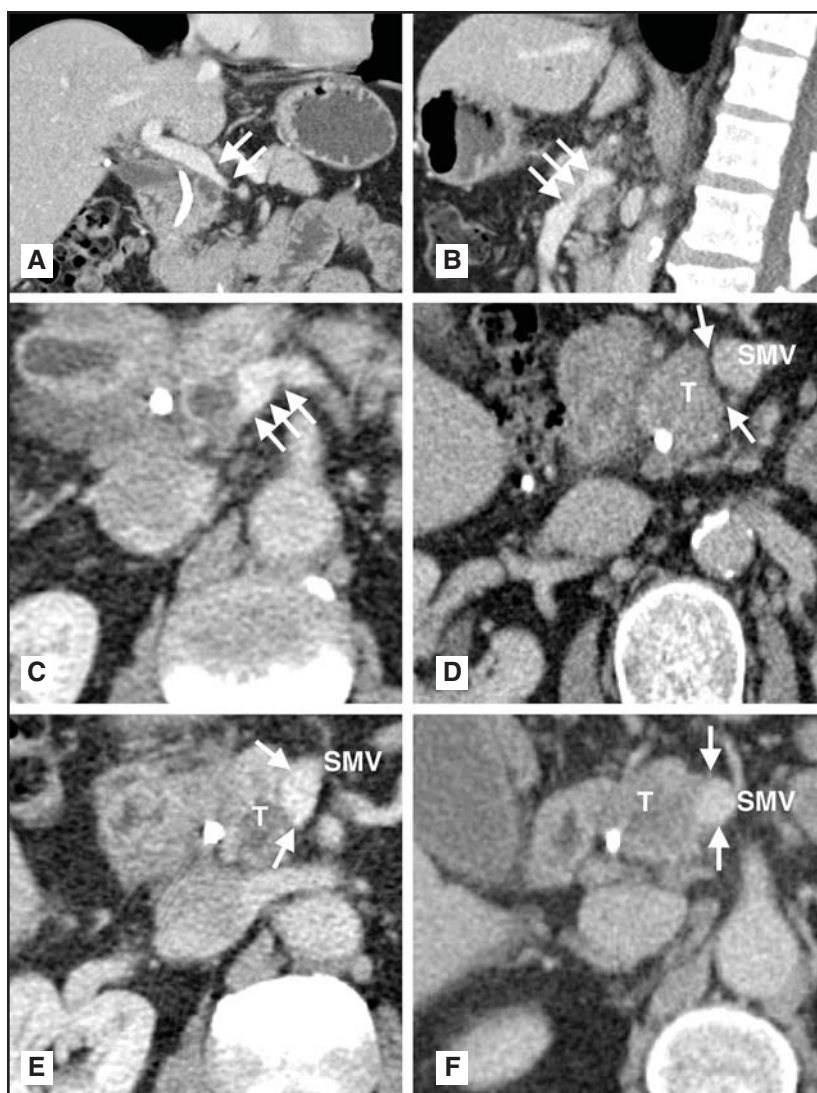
Multidetector high-resolution CT scans in staging pancreatic cancer. Coronal (A) and sagittal (B) reconstructed images of a patient with an unresectable pancreatic tumor that encases and constricts the PV (arrows). (C) Teardrop deformation of the PV/SMV that abuts a pancreatic tumor for 180°. Varying degrees of SMV abutment (D-F) with tumor (T). (D) No SMV abutment. (E) < 180° SMV abutment. (F) 180° SMV abutment.
